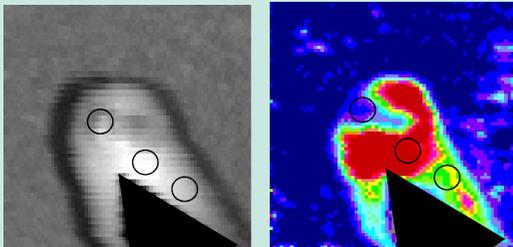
An example of a laser Doppler image showing the black and white image of the ulcer (left) and perfusion map (right). Red represents relatively high blood flow and blue low blood flow. Reduced blood flow at the tip of the finger, at the site of the ulcer can be clearly seen. The 3 circles represent the positions at which measurements of perfusion are made: at the ulcer site, adjacent to the site and distant from the site.
